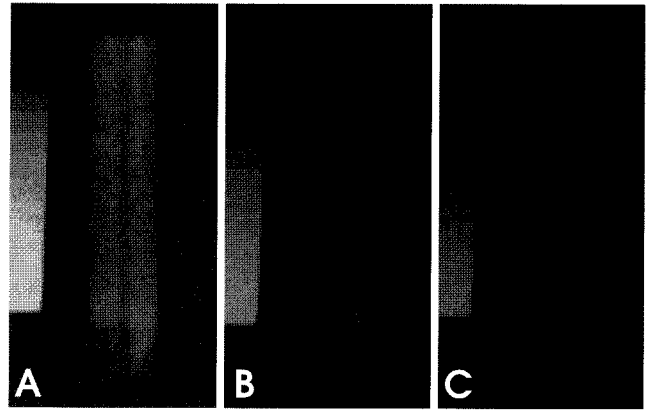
Radiographs which were obtained at different kV: (A) 60 kV; (B) 75 kV; (C) 90 kV.
